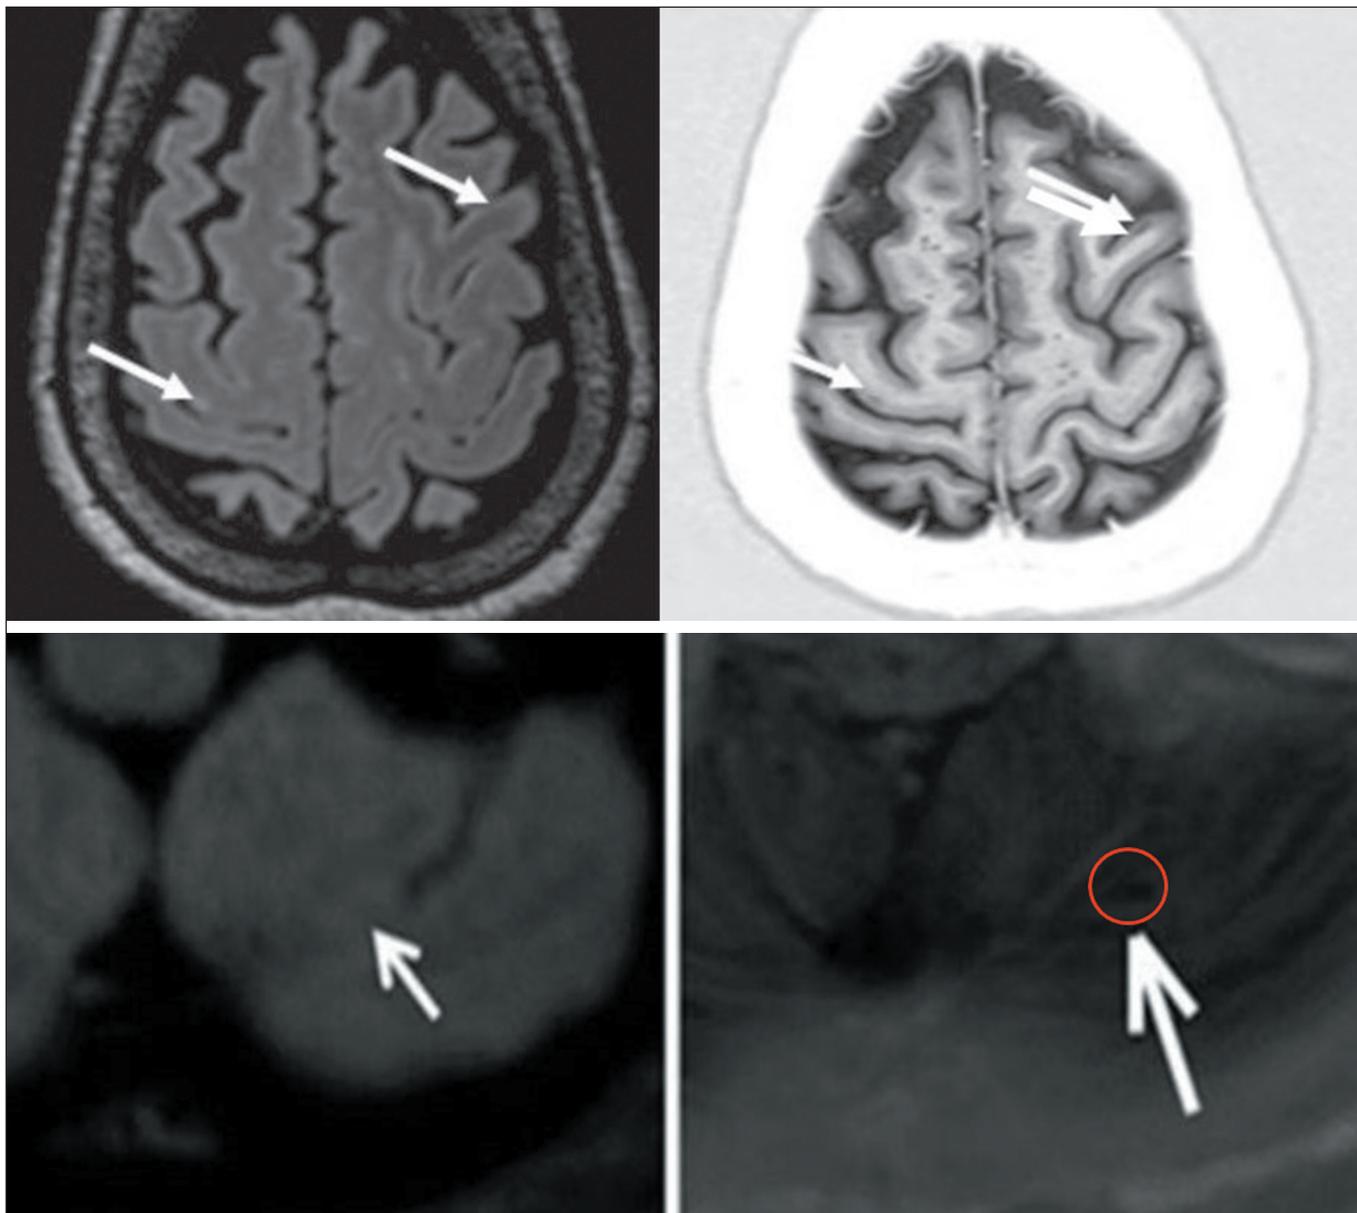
Lesions detected only on PSIR sequences. Axial 3D FLAIR (left) and axial PSIR (right): intracortical (type I) lesion (top) in the right precentral gyrus and left middle frontal gyrus; and infratentorial lesion (bottom).
